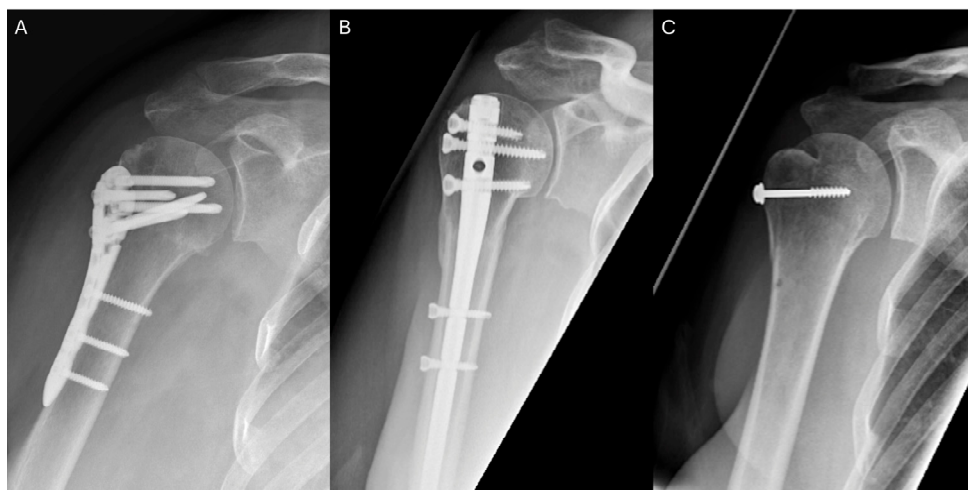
Open reduction internal fixation. Three alternatives to open reduction internal fixation for proximal humeral fractures. A: Locking plate. B: Intramedullary nail. C: Screw fixation combined with sutures (the sutures are not visible on the radiograph; however a hole in the humeral shaft, used for suture fixation, is identifiable). Radiographs photographed by the author.
